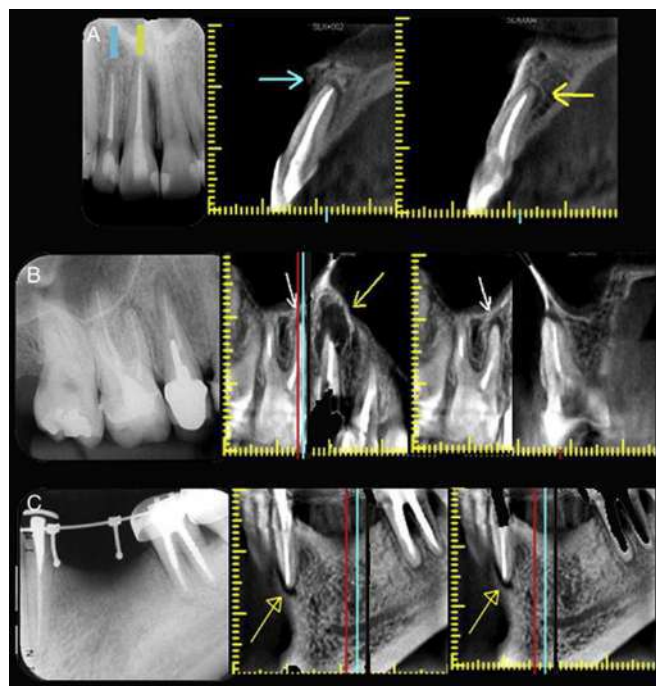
2. In x-ray periapical lesion is not seen in maxillary anterior but is clearly seen in CBCT image
